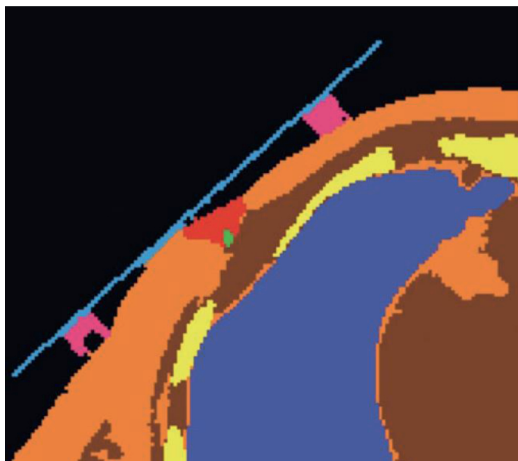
Axial CT image of breast tissue demonstrating tumor (*red*), catheter in tumor (*green*), fat (*orange*), muscle (*brown*), bone (*yellow*), air (*blue*), moulds (*light blue*) and stubs (*pink*).
